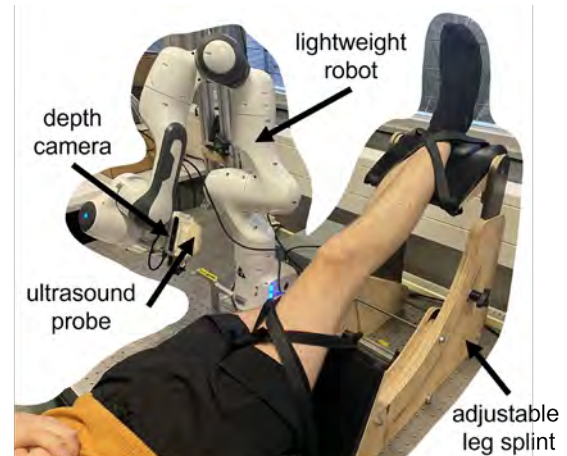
Autonomous robotic ultrasound scanning of the knee
